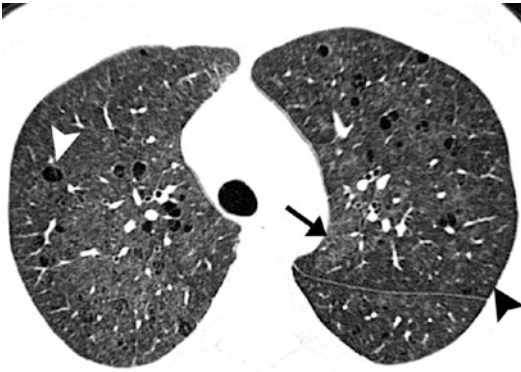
LIP in a 44-year-old woman with Sjögren syndrome. Axial CT image shows several thin-walled cysts (*white arrowhead*), bilateral patchy ground-glass opacities (*arrow*), and poorly defined centrilobular nodules (*black arrowhead*)
